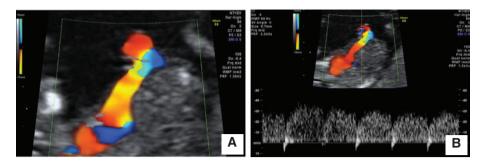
Ultrasound images performed at 16 weeks + 4 days: (A) depiction of a large vessel, without any funneling, connecting the umbilical vein to the right atrium, (B) blood flow waveform obtained by pulsed Doppler from a region with aliasing, showing higher velocities than those normally obtained from the umbilical vein and no retrograde flow.
